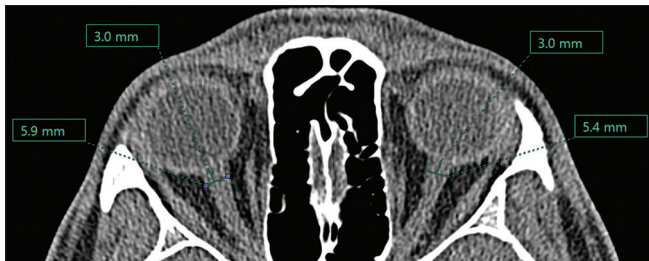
Computed tomography image axial plane showing optic nerve sheath measuring 5.9 mm in the right eye and 5.4 mm in the left eye
